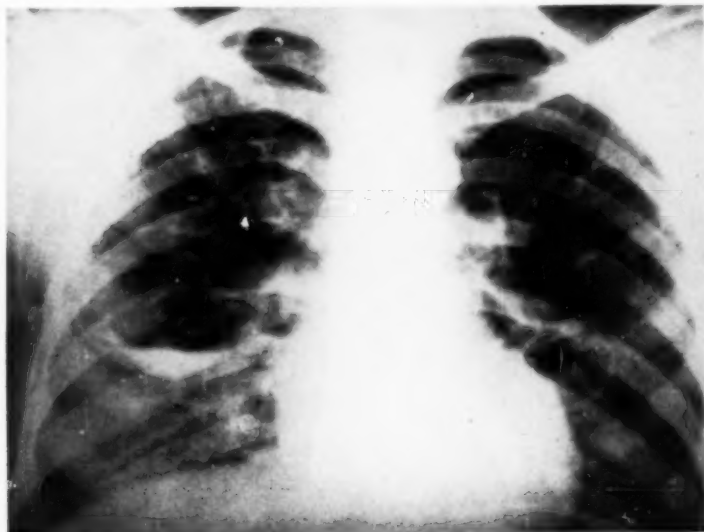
Case 6 (routine roentgenogram).
